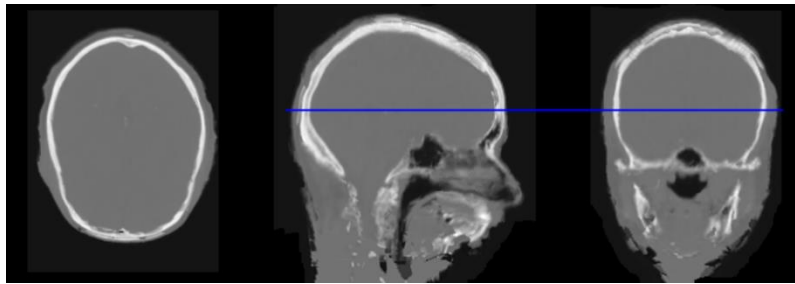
Returned pseudoCT which results from the provided target MRI (see Figure 5), optimized for accuracy
